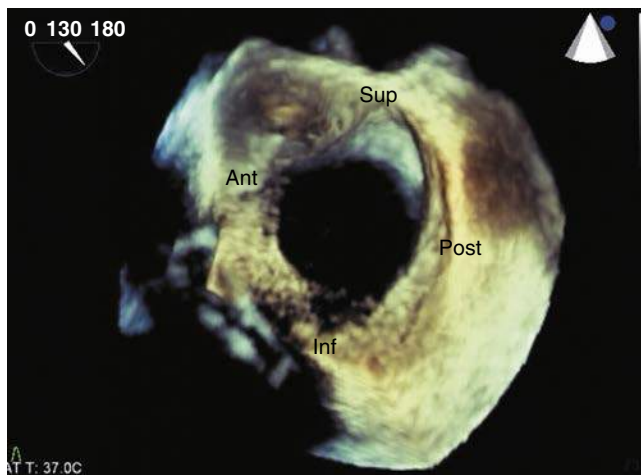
Three-dimensional transesophageal echocardiogram of a large ostium secundum atrial septal defect viewed from the left atrium. Notice the absence of the superior rim. Ant, Anterior rim; Inf, inferior rim; Post, posterior rim; Sup, superior rim. (Courtesy Wei Li, MD, PhD, Royal Brompton Hospital and the National Heart & Lung Institute, Imperial College, London, United Kingdom.)
